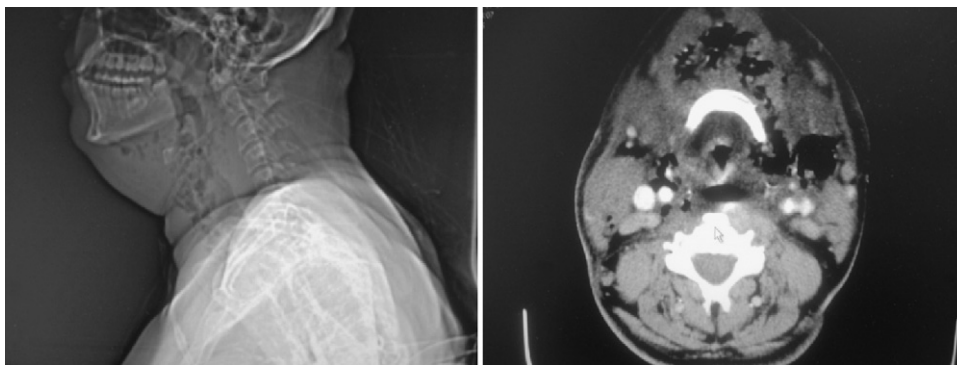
Preop CT. (A) CT topogram showing extensive air in anterior neck and submandibular region. (B) Axial view below level of mandible showing air in the anterior and bilateral neck region.
